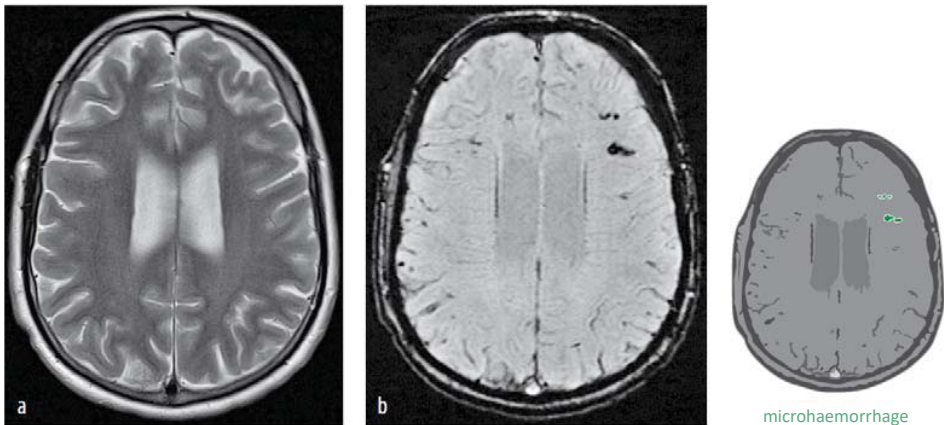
MRI-scan of the cerebrum of patient A, 4 months after sustaining a skull base fracture (transversal coupes).
